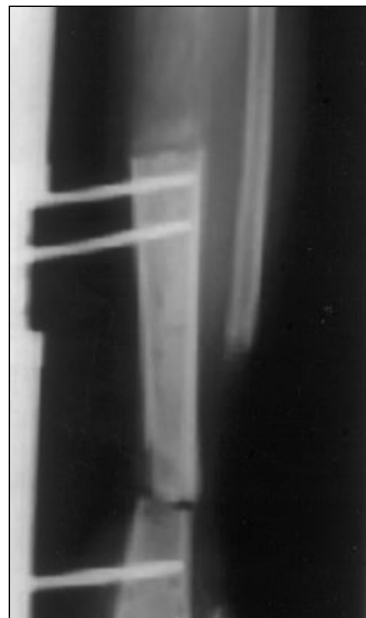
Radiograph after debridement and application of the limb reconstruction system (Orthofix) and collapse of 10 cm of tibia, and distraction osteogenesis at proximal corticotomy site
